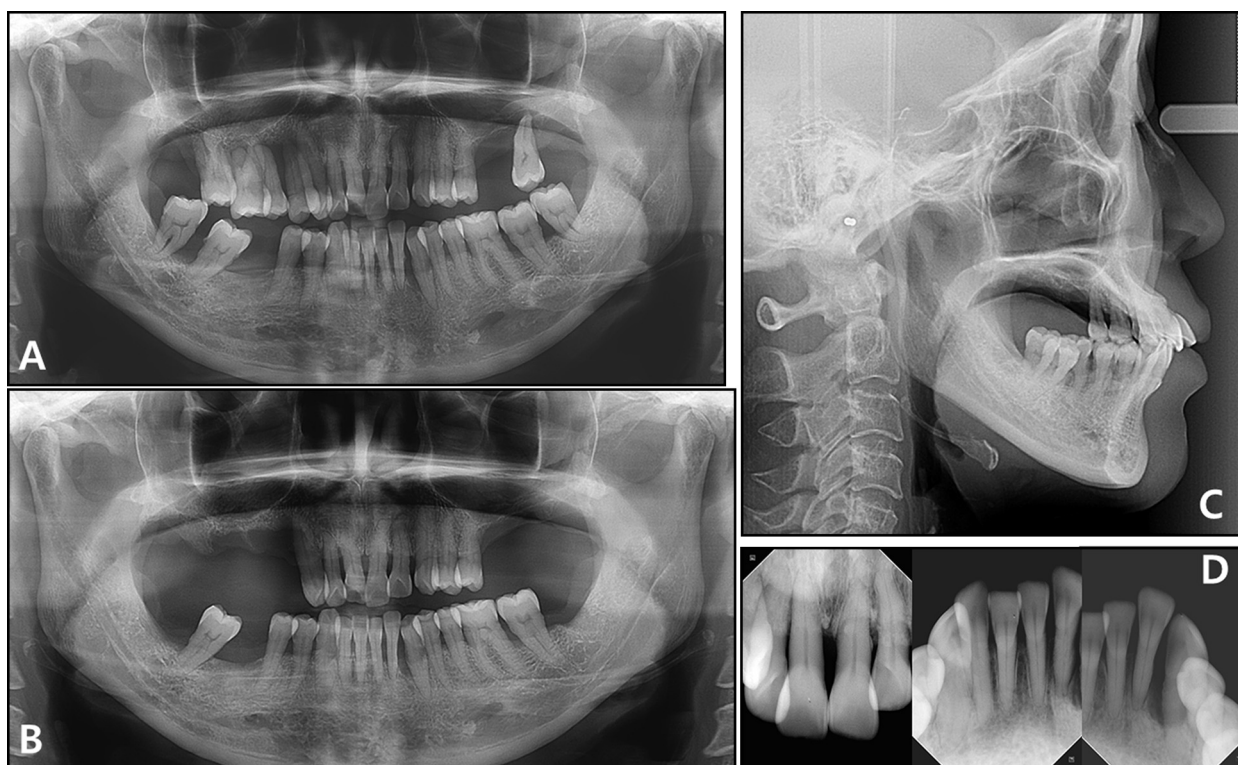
Pretreatment radiographs: A, panoramic radiograph before periodontic treatment; B, panoramic radiograph after periodontic treatment; C, lateral cephalogram; D, periapical radiographs.
